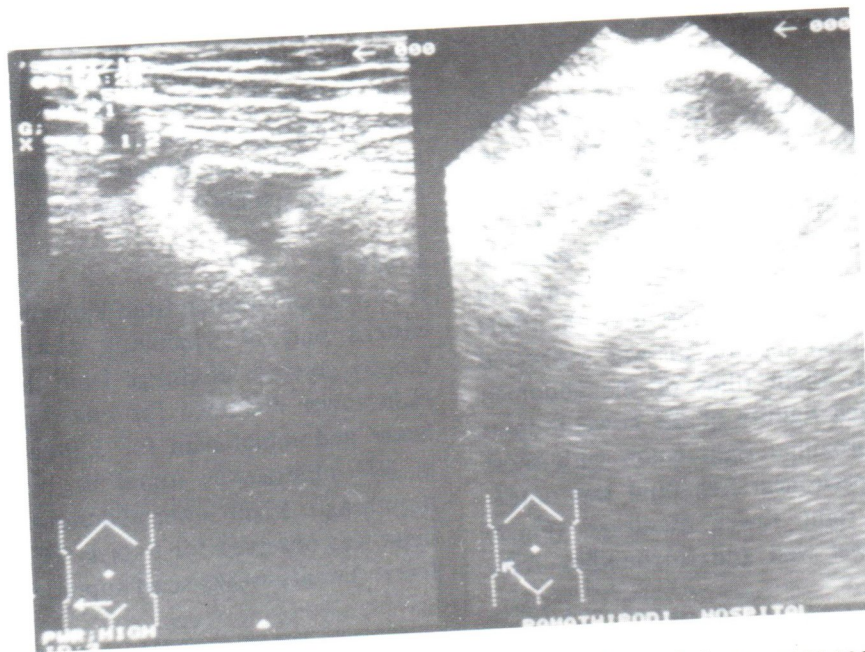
Case 1. Fluid collection at RLQ and around bowel loop, was seen at ultrasonographic examination.
